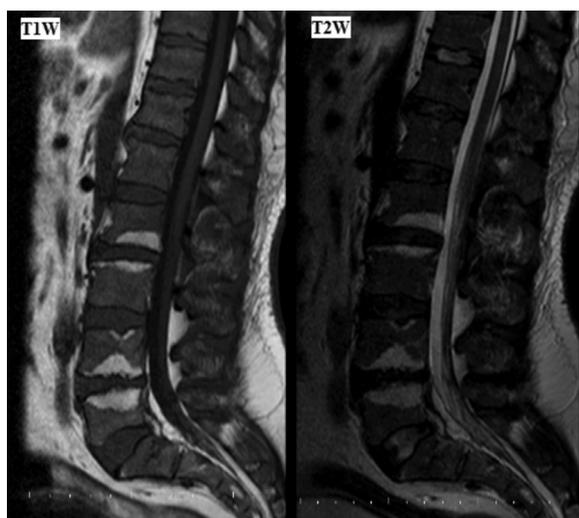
Magnetic resonance imaging of the lumbar spine in one of our patients, Modic type II lesions (hyperintensity on T1- and T2-weighted images) at the L2-L3 and L4-L5 disc levels
